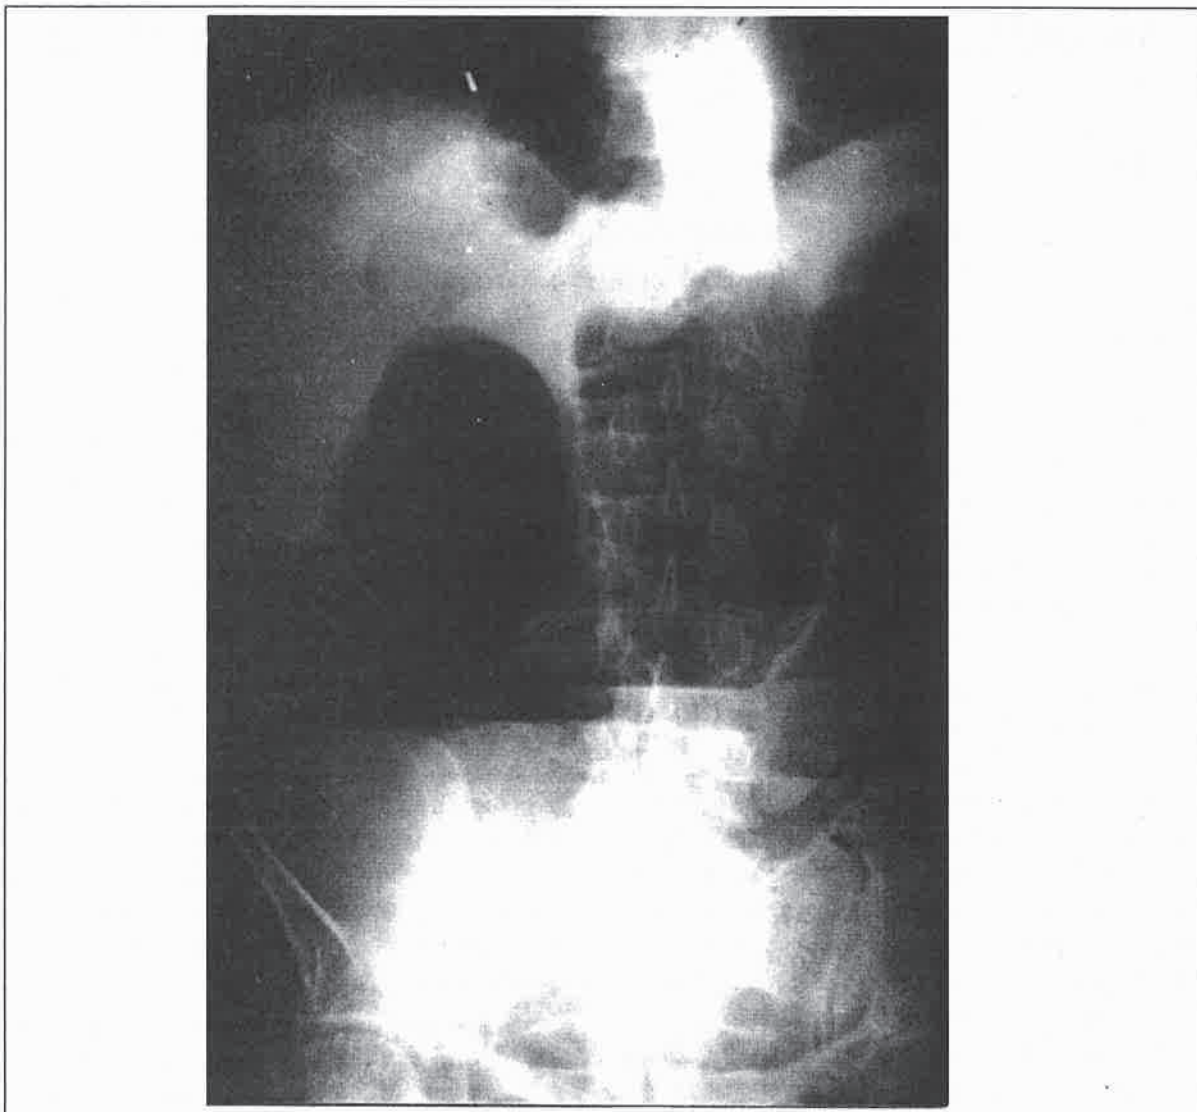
An abdominal x-ray shows a distended bowel loop in the paraesophageal area, air-fluid levels and distended bowel loops in the abdomen.
